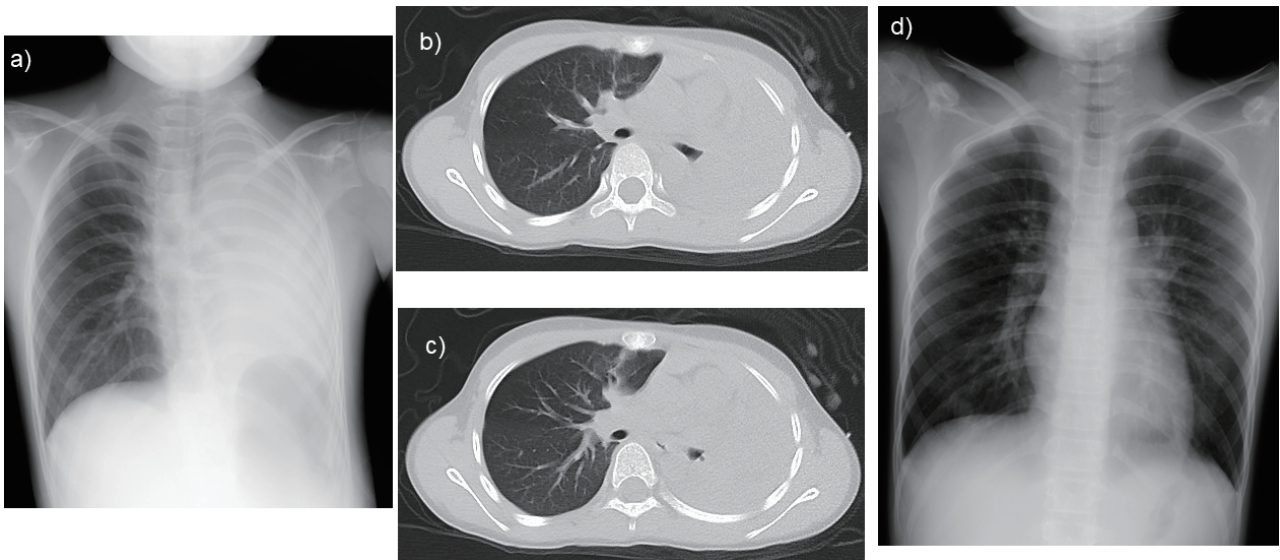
Chest radiograph and computed tomography
